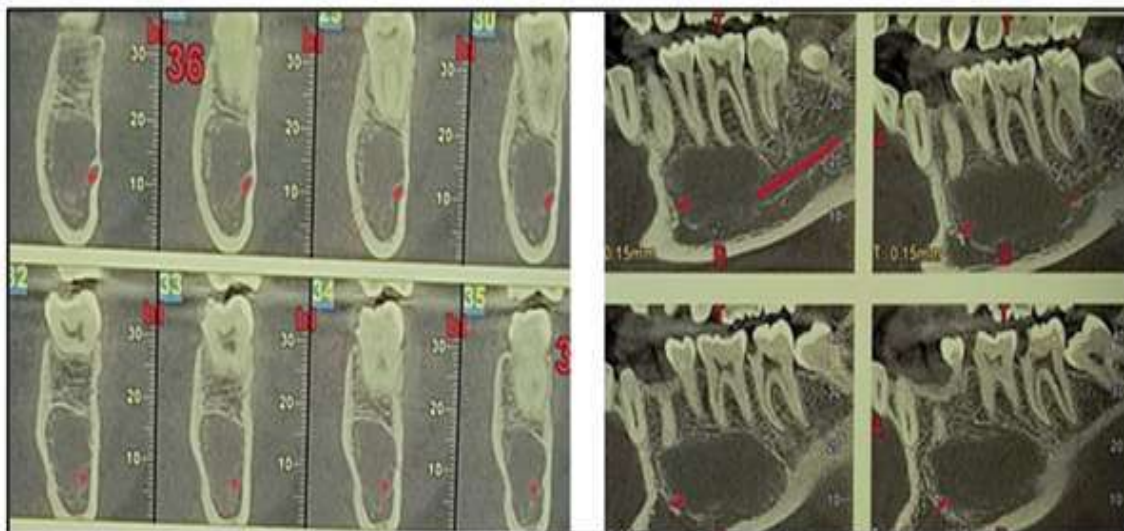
Cone Beam Computed Tomography showing a hypodense area without any buccal or lingual cortical layer perforation or root invasion.
